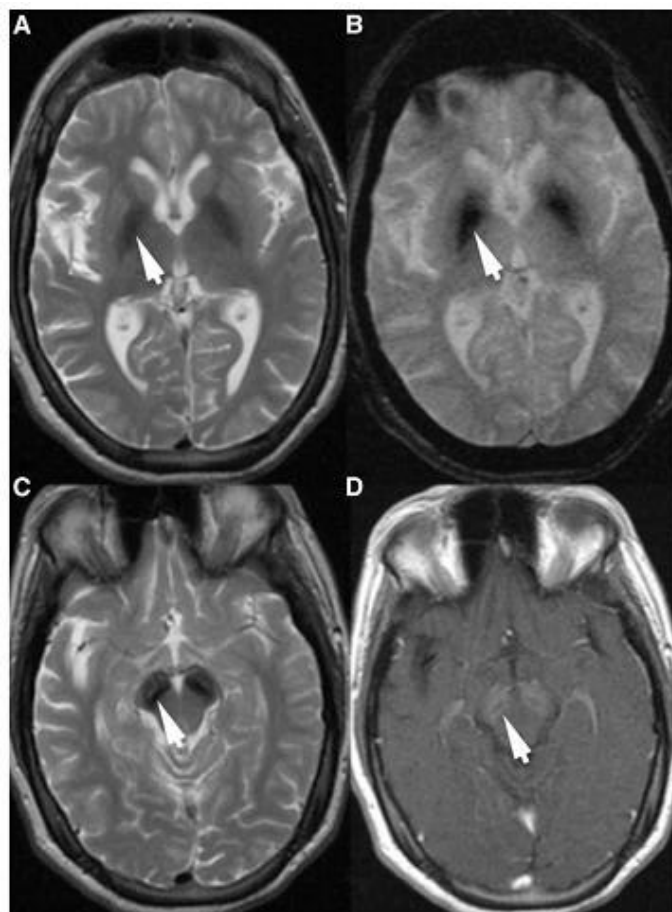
Axial MR imaging of an individual with BPAN
